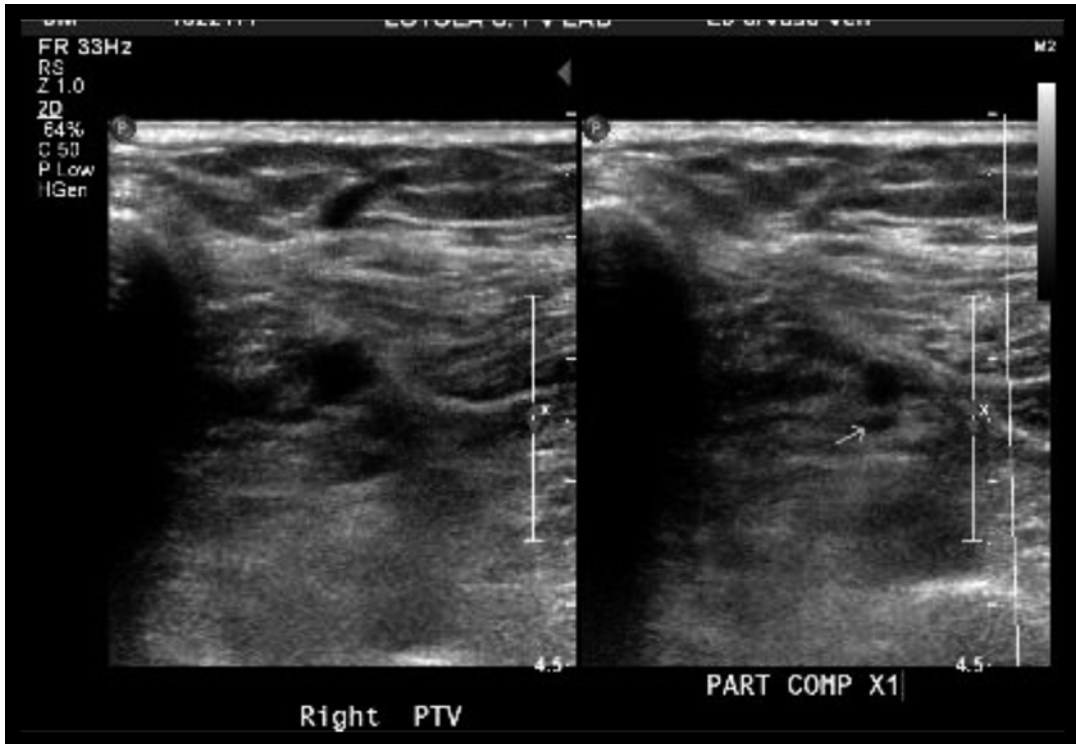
Lower extremity venous duplex ultrasound demonstrating evidence of an acute deep venous thrombosis of the posterior tibial vein
